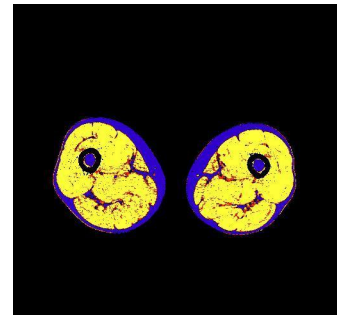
Mid-thigh CT image using Mipave plug-in. SF is represented in blue, HDM is highlighted in yellow and LDM is highlighted in red.
